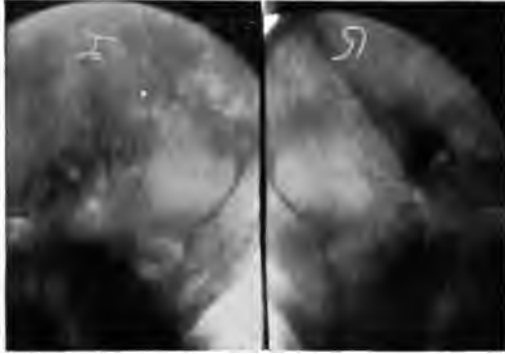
CASE 7576. FEMALE AGE 30. SAME TYPE AS ROENTGENOGRAM FIG. 10.
